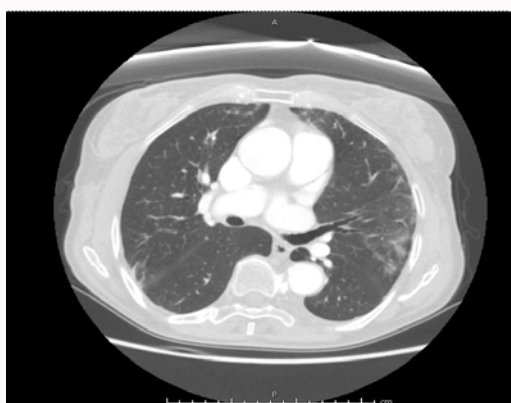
Case 1: Bilateral lung infiltrates found on restaging CT scan in patient with mild symptoms.
